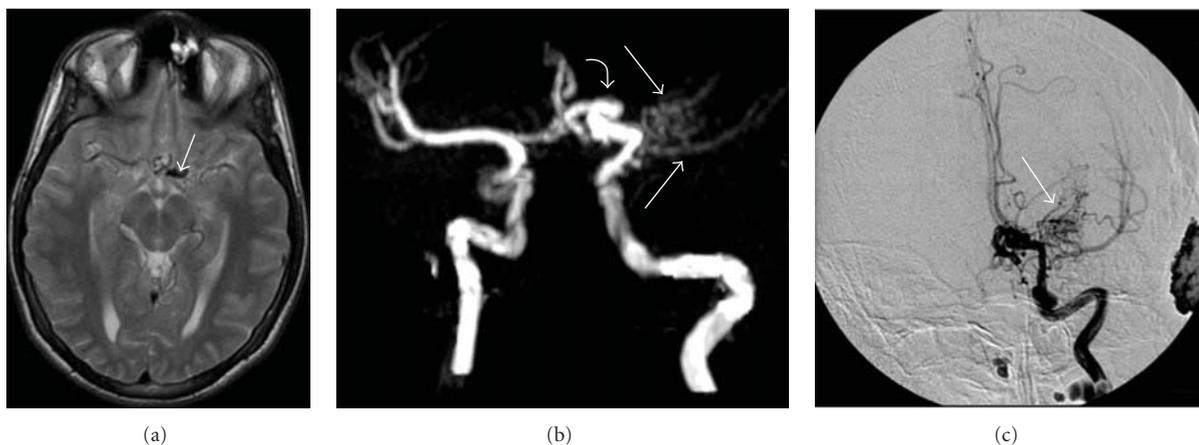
A 15-year-old male presenting with transient right hemiparesis. (a) MRI T2-weighted Turbo Spin Echo image shows vascular abnormality in left portion of the circle of Willis (arrow). (b) MR-angiogram shows a progressive reduction of diameter of the supraclinoid internal carotid artery associated with occlusion of the origin of left middle cerebral artery (curved white arrow) and presence of tiny newly formed compensatory network (white arrows). (c) Intra-arterial digital subtraction angiography better shows the occlusion of left middle cerebral artery and the typical presence of tortuous tiny vessels appearing as the so-called “puff of smoke” (“moya-moya”) (arrow), formed to compensate for the supply blockage.
